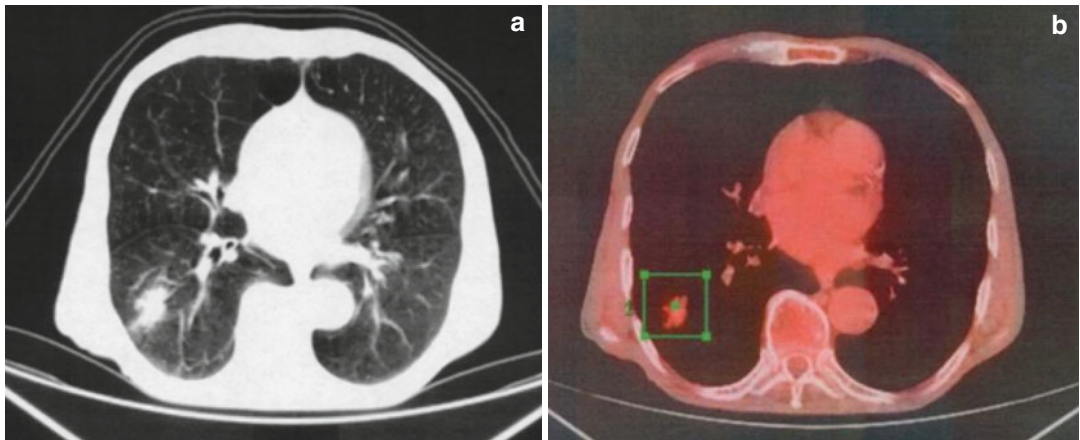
(a, b) Axial CT (a) and corresponding axial fused PET/CT (b) image of the chest reveal a hypermetabolic lesion in the lower lobe of the right lung
